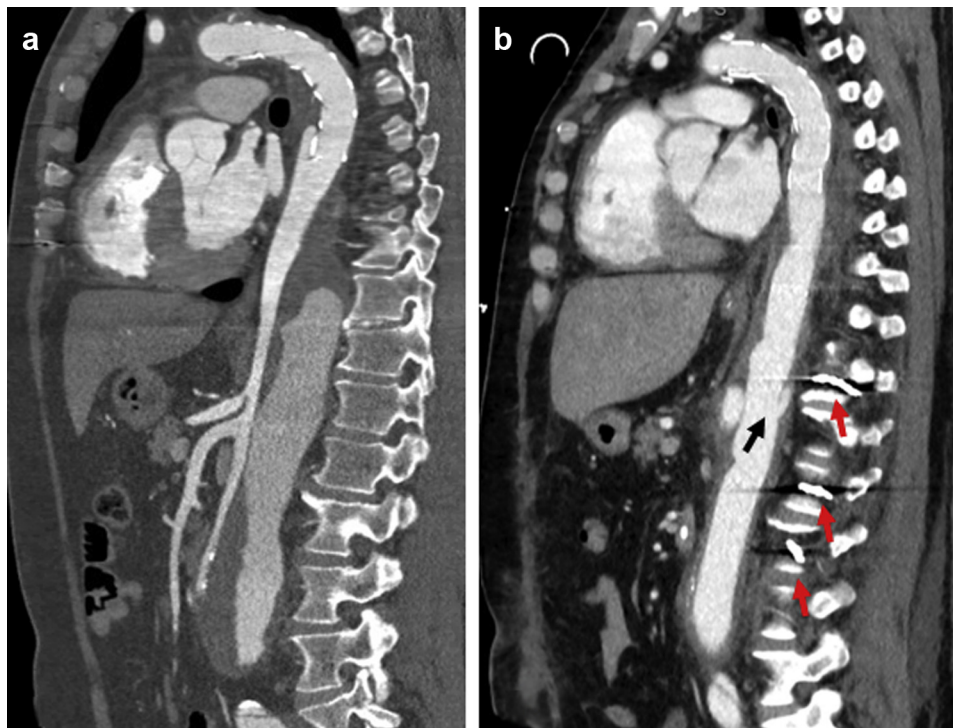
Computed tomography scan of the thoracoabdominal aorta preoperatively (*a*) and postoperatively (*b*). The *black arrow* points to the bypass for the segmental arteries (SAs); and the *red arrows* to the coils in the SAs.
